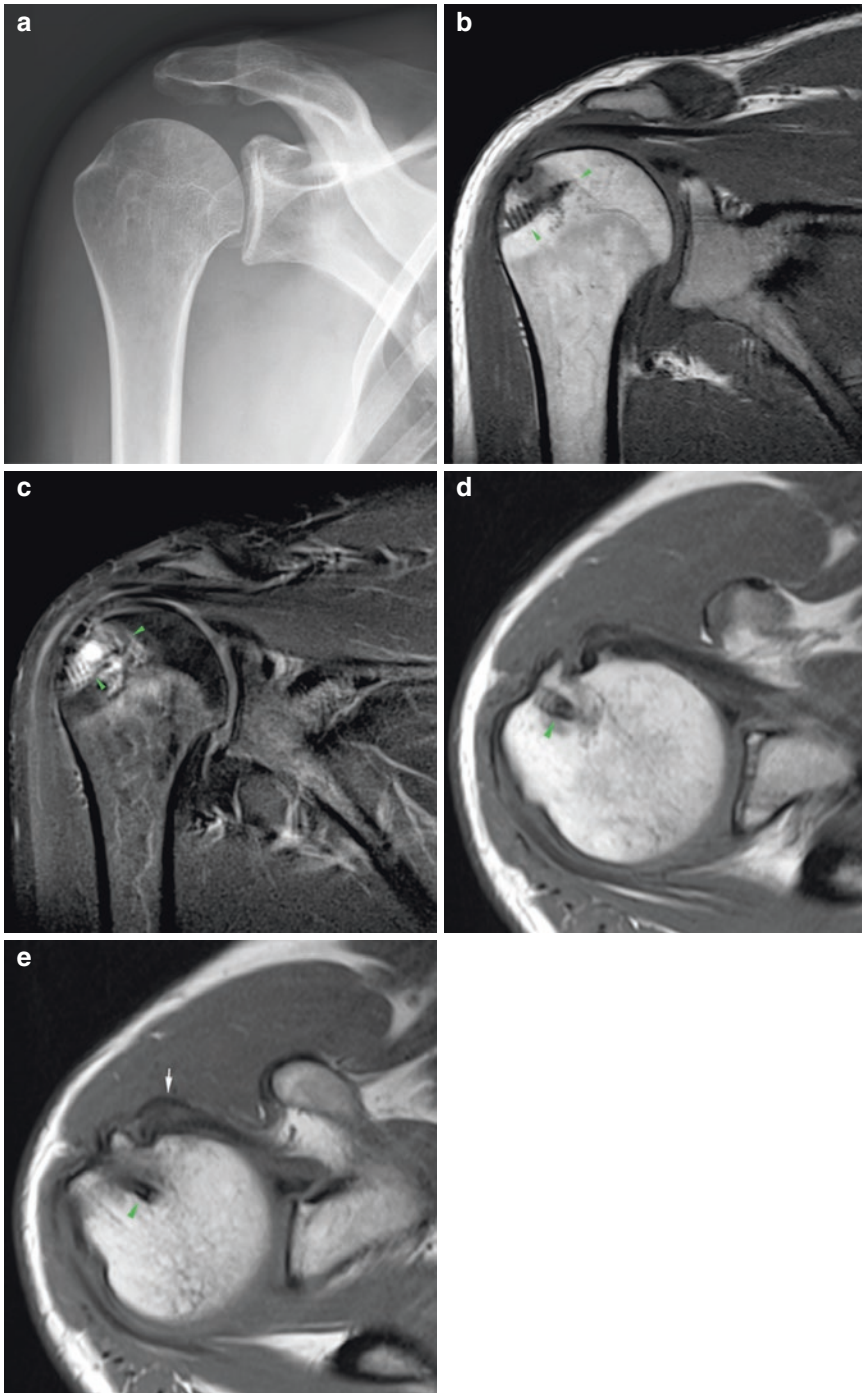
(a–e) Nonmetal suture anchor artifact. (a) Frontal radiograph of the shoulder post supraspinatus reinsertion. The bioabsorbable suture anchor is not appreciated on the radiograph. There are small calcifications in the acromioclavicular space. (b) T1-weighted coronal MR image. The nonmetallic anchor is readily seen with no significant artifact (arrowheads). Normal osteointegration of the anchor. (c) T2-weighted FatSat coronal MR image.
